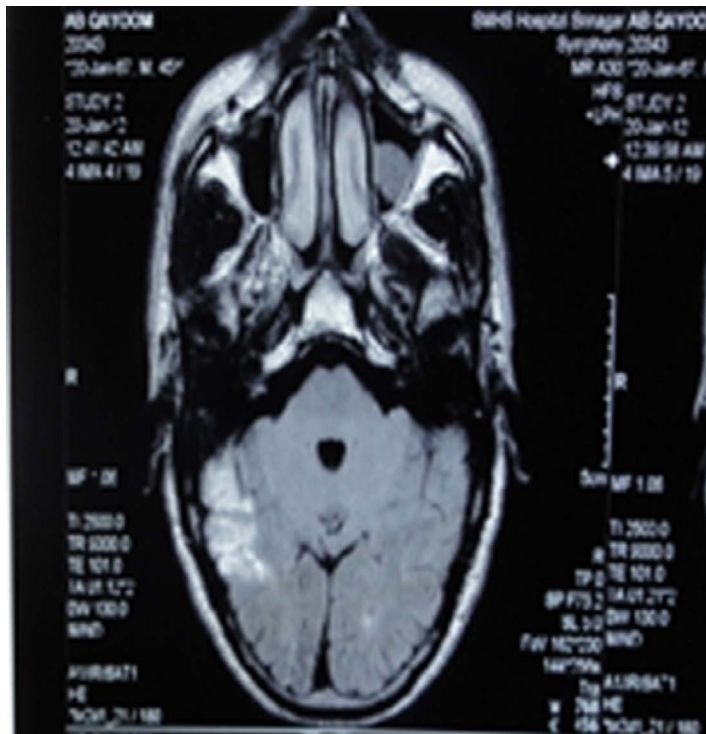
MRI of the brain; T2W (axial section) showing infarct in the right PCA territory.
